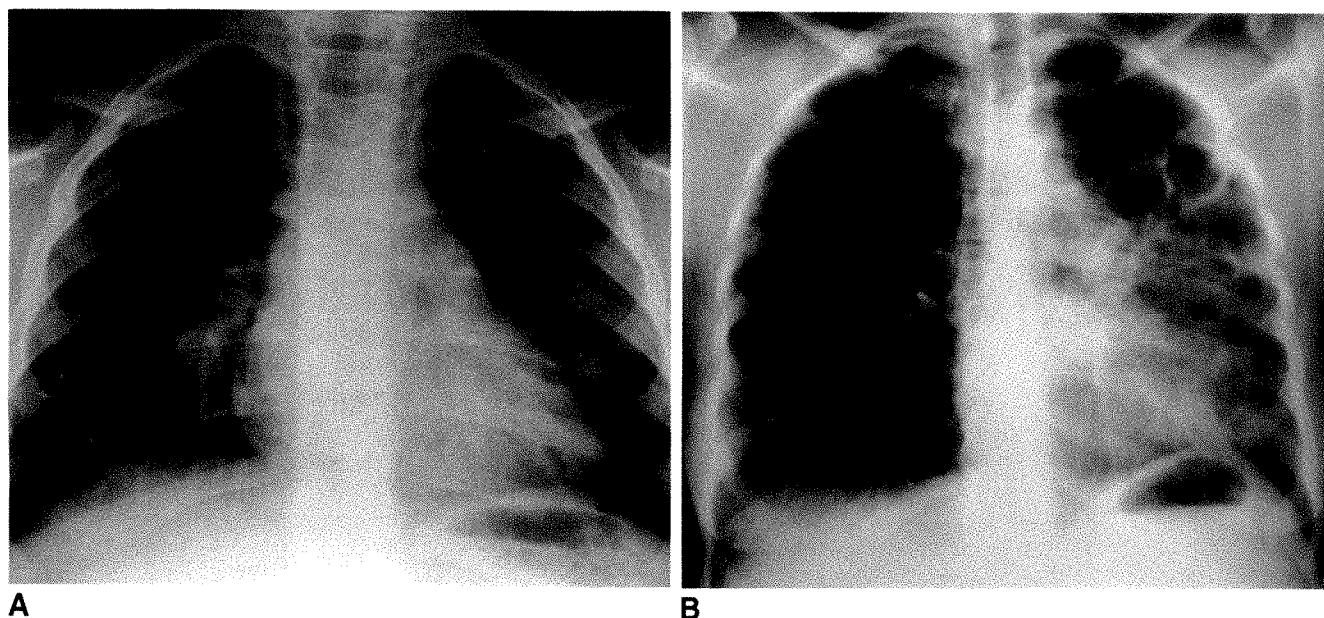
A, Anteroposterior chest radiograph reveals subtle alveolar disease in right lower lobe and hilar adenopathy in an asymptomatic 3-year-old child referred for evaluation of a positive purified protein derivative (PPD) skin test. The child's mother had been experiencing night sweats, weight loss, a productive cough, and fatigue for several months before she presented with pneumonia. Her sputum smear was positive for acid-fast bacilli.
